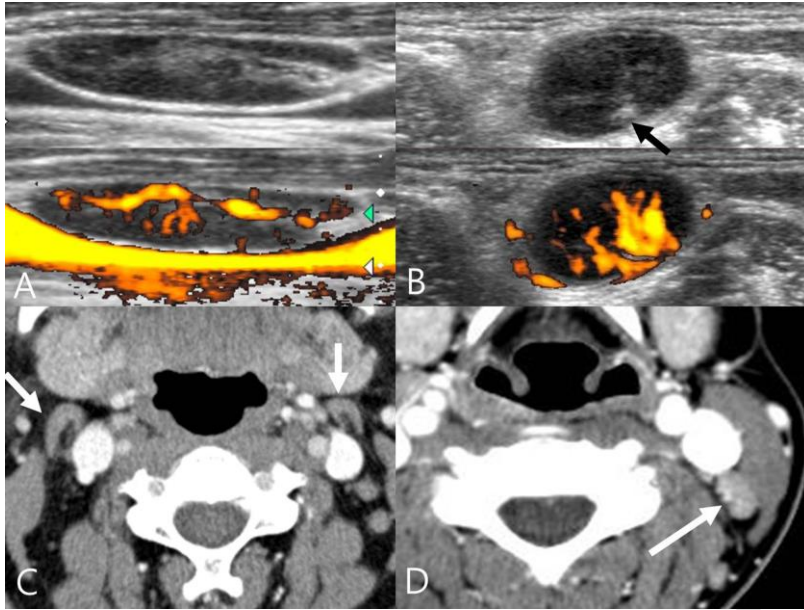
Benign lymph nodes. A, B. The US features of the benign lymph nodes. The US image shows an elongated lymph node with a prominent central echogenic hilum and central hilar vascularity (A). The US image shows an ovoid lymph node with a small deformed echogenic hilum (arrow), however, color-Doppler US shows the prominent typical central hilar vascularity (B). C, D. The CT features of the benign lymph nodes. The CT image shows a lymph node with a central hilar fat (C, arrows) and an enhanced lymph node with central hilar vessel enhancement (D). Diagnosis: Benign lymph node (A, B, C, D, FNA not performed).
